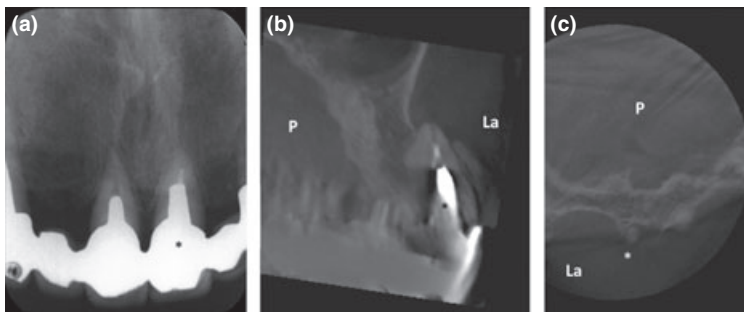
Type V-2: The apical one-third of the root and apical foramen of the maxillary left central incisor (*) were extruded from the labial bone plate. (a) Periapical radiograph. (b) Labio-palatal slice image of the CBCT (3DX). (c) Horizontal slice image of the CBCT (3DX). La: labial side. P: palatal side.
